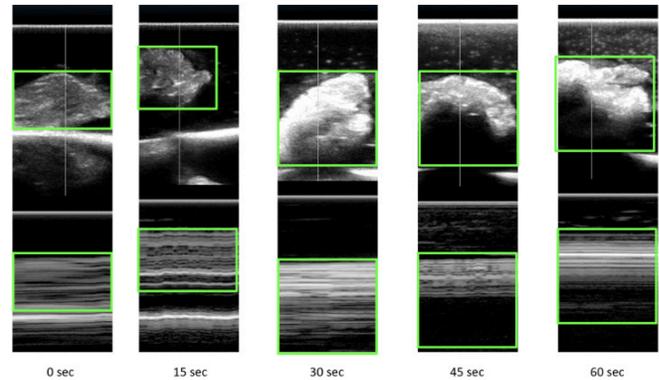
M-mode ultrasound reflection with increasing duration of exposure to microwave energy. The top image is a 2D conventional ultrasound with a line to designate the place on the image that pixels are collected. These pixels are spread out on the bottom image with depth as a vertical axis and time as a horizontal axis. A green box outlines the chicken tissue observed in both the 2D ultrasound and M-Mode.
